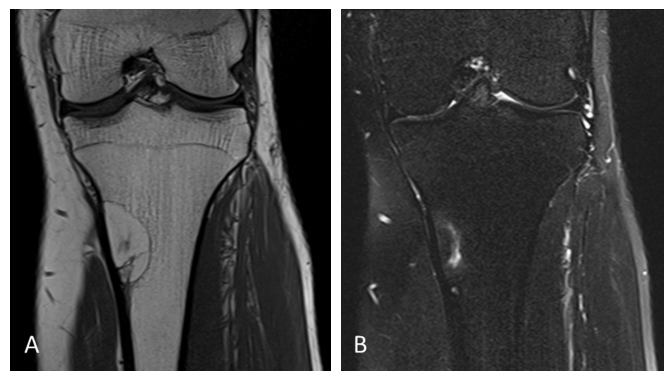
A) Coronal T1-weighted MR image shows a well defined hyperintense lesion, with signal intensity similar to that of subcutaneous fat, in the medial proximal tibia. It has a thin hypointense rim corresponding to the sclerotic margin and an irregular internal low-signal-intensity area corresponding to fat necrosis. B) Corresponding coronal T2-weighted MR image with fat suppression shows a largely hypointense lesion consistent with suppression of fat signal. The central hyperintense area within the lesion is consistent with fat necrosis.
